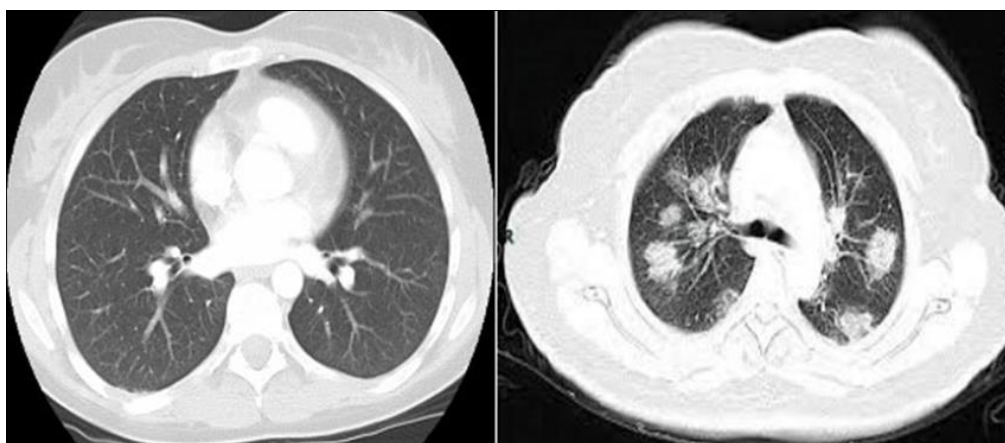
Left side shows CT image of healthy lungs in 40 year woman and Rightside image shows chest CT image of COVID infected person interpreting subpleural curvilinear opacity (arrow) and an area of ground-glass opacity with superimposed septal thickening (arrows) in a 50 year old woman
